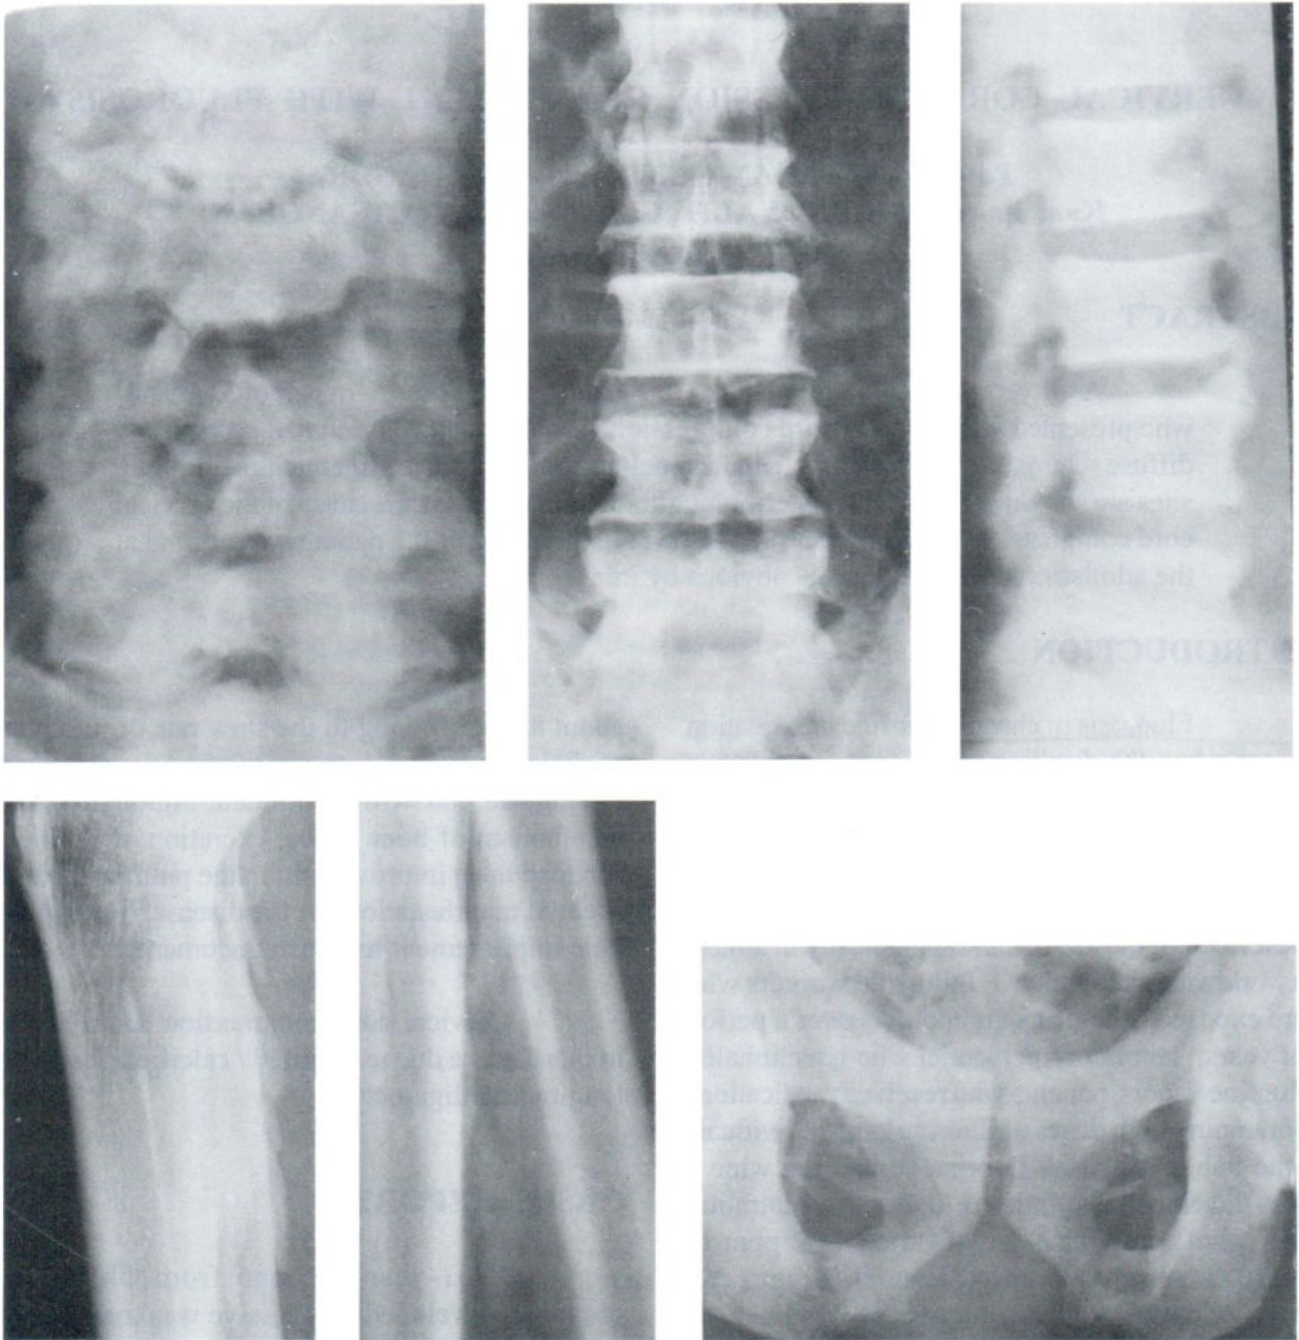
Radiographic images of axial skeleton, ribs and pelvic bones and limbs which showed diffuse osteosclerosis, osteophytosis, periostitis and ligamentous calcification.
